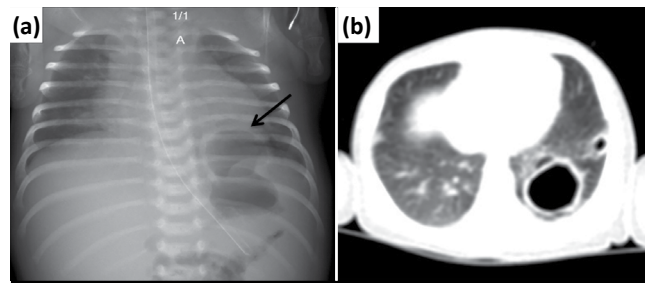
(a) Shows cystic like hyperlucent area on the left posterior-basal segment of the lung (arrow). (b) Thoracic computed tomography confirms cystic changes in the left lower lobe, the largest of them is located in the left lower lobe posterior basal segment
